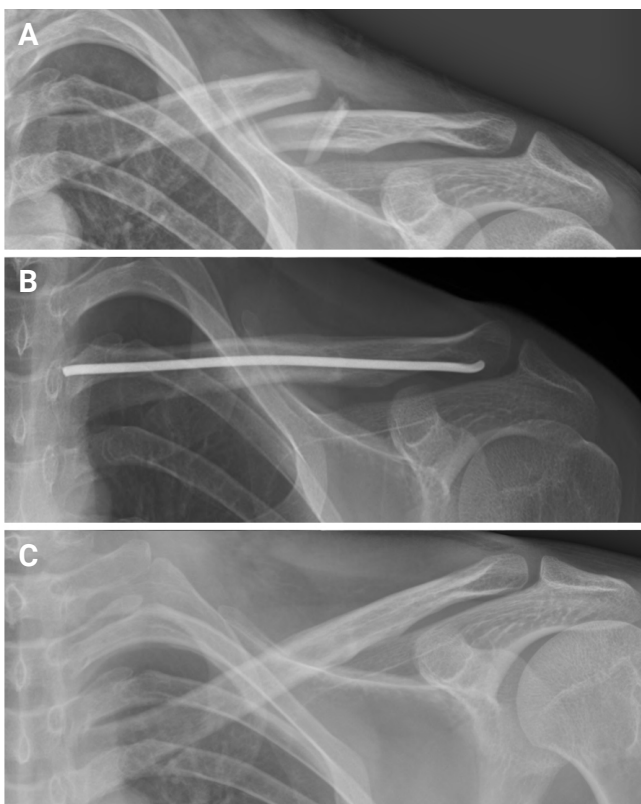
A 24-year-old man with a left-sided displaced mid-shaft clavicle fracture underwent intramedullary nailing. (A) The preoperative radiograph shows a midclavicular fracture (Robinson 2B1). (B) A radiograph at 1 year postoperative shows successful union of the fracture with the nail. (C) After implant removal, the radiograph shows persistent union.
